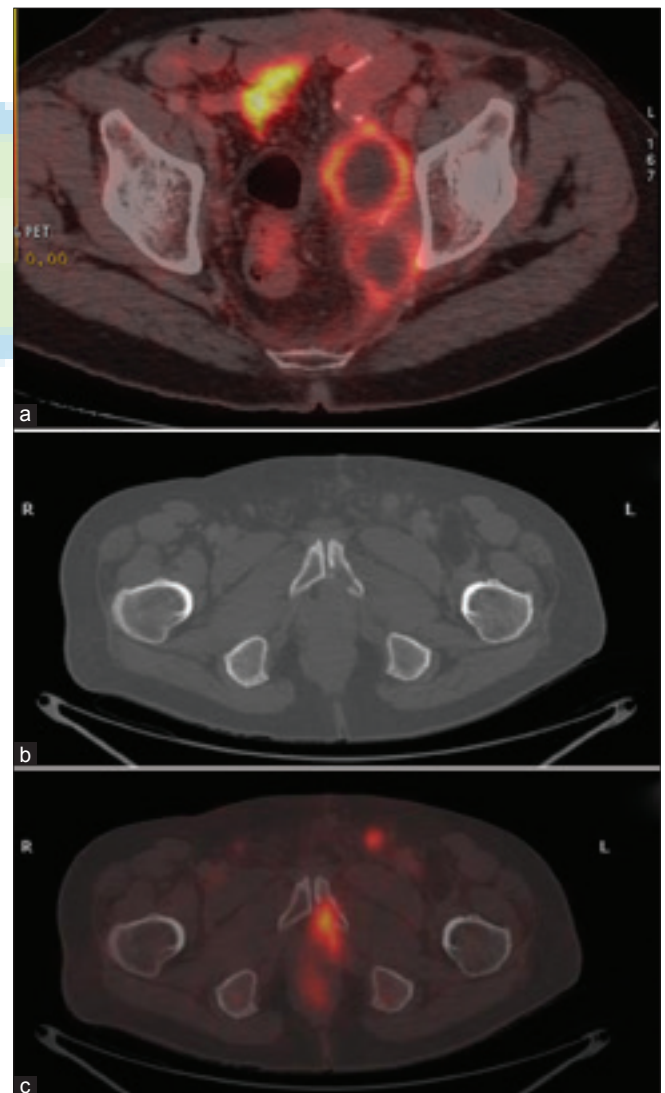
Pre-therapy trans-axial PET/CT images. (a) Intense uptake in the periphery of necrotic left external iliac lymph node. Trans-axial CT image of the pelvis. (b) A lytic lesion in the left pubic symphysis while PET/CT image. (c) FDG uptake in lytic lesion as well as in a left inguinal lymph node
